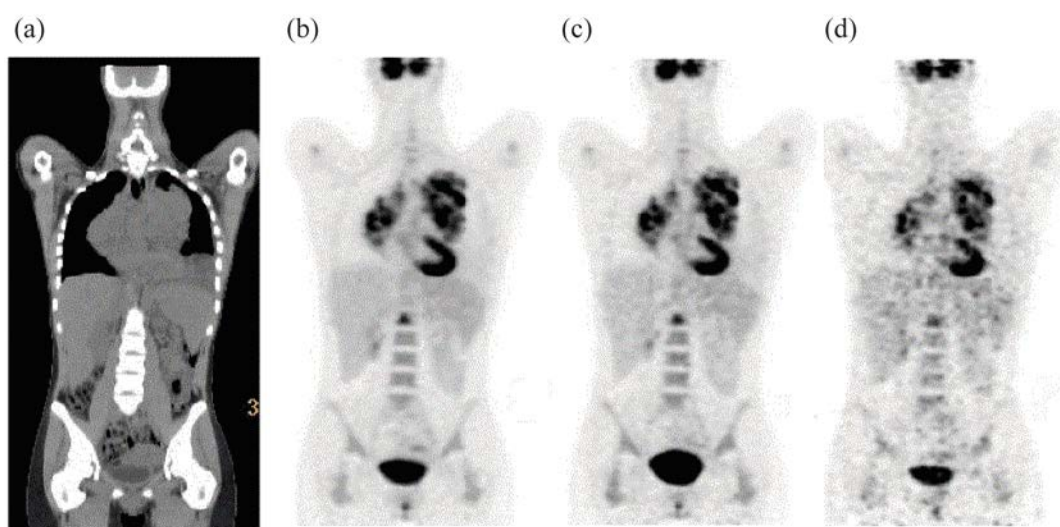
Whole body FDG-PET/CT study of a female patient with lymphoma. The injected activity was 270 MBq and PET/CT scanning started at 60 min post-injection. After acquiring a topogram and a CT (a), a 6-bed list mode emission scan was acquired for 3 min per bed position. AC-PET images are shown for a total emission scan time of 18 min (b), 6 min (c) and 1 min (d). AC: attenuation corrected.
